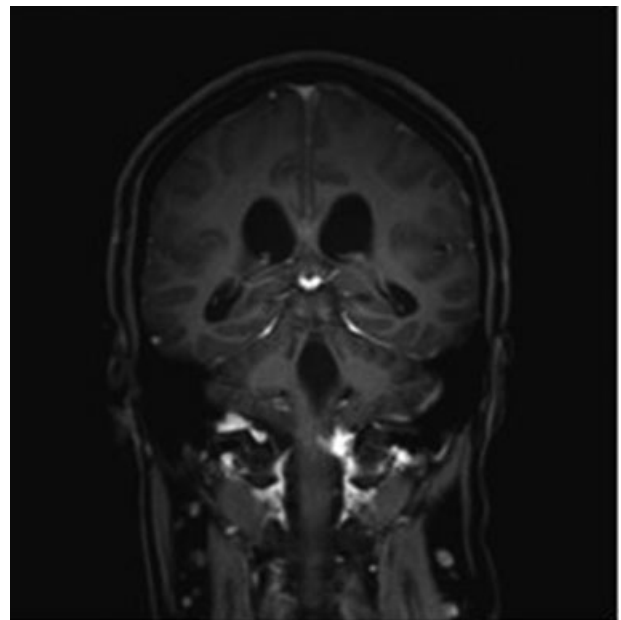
Postoperative encephalon T1-weighted MRI scan with contrast in the coronal section, showing complete resection of the tumor lesion, with centralization of the brainstem and free fourth ventricle.
